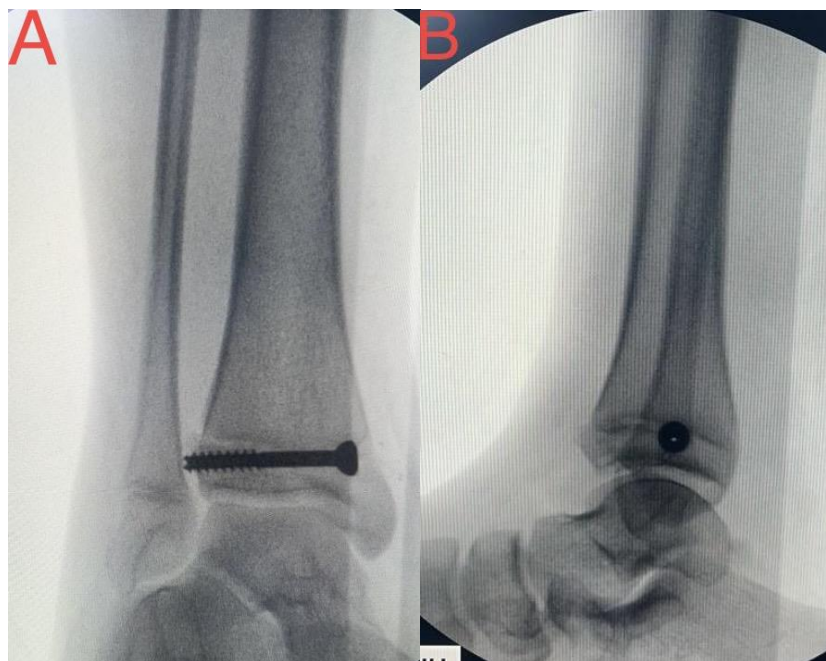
Postoperative plain radiographs following reduction and fixation of the Tillaux fracture. (A) Anterior-posterior (AP) view and (B) lateral view demonstrate satisfactory alignment. The cannulated screw traversing the distal tibia is clearly visible in both projections, confirming reduction of the displaced fragment. AP = anterior-posterior.
